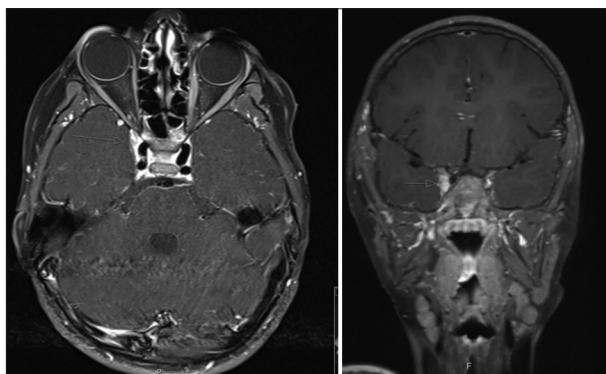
Magnetic resonance imaging T1 with contrast and fat suppression protocol. Axial and coronal cuts demonstrate thickening of the right cavernous sinus, originating in its anterior-lateral aspect and advancing toward the orbital apex (gray arrow)
